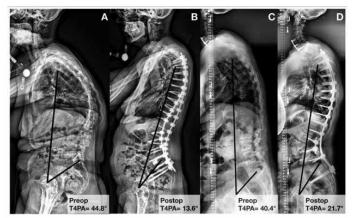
A. Preoperative and B. Postoperative radiographs of a 63-year-old patient who underwent T3-S1/ilium fusion with correction close to normative alignment (T4PA offset from normative= -0.48°), resulting in PJF. C. Preoperative and D. Postoperative radiographs of a 65-year-old patient who underwent T3-S1/ilium fusion with correction close to optimal alignment (T4PA offset from optimal=0.11°), resulting in no PJF.
